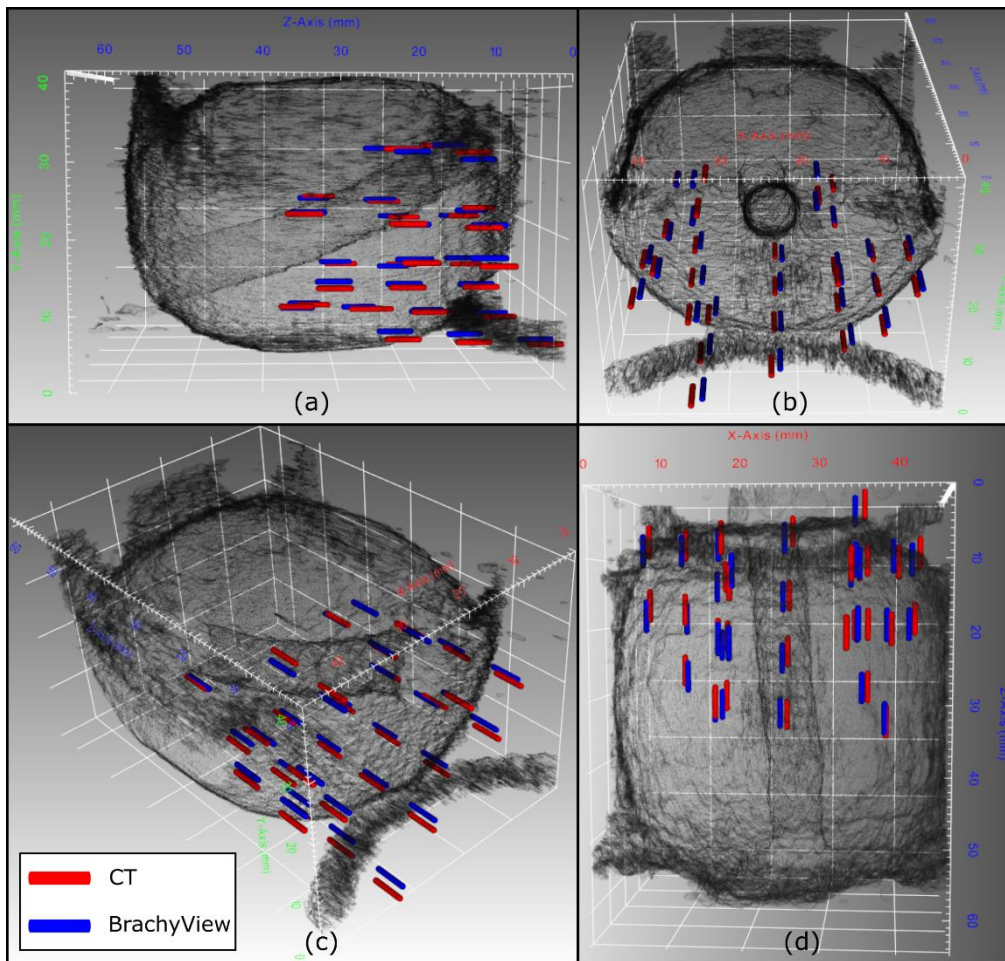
Screen shot of software interface depicting 3D prostate model reconstructed from US images with reconstructed seed positions from both the BrachyView and CT data set co-registered into a single coordinate system.
